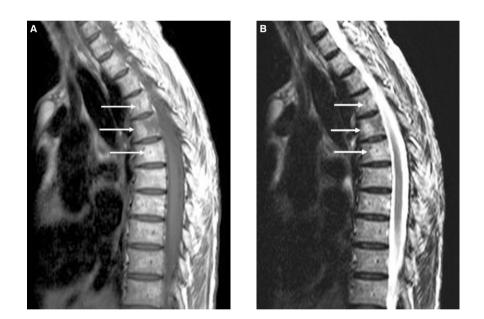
MRI of the spine was performed to clarify the above findings. T1 and T2 weighted sequences (Figures 4A and B respectively) show high signal on both sequences in several vertebrae, which is the typical appearance of vertebral haemangiomas [1].
